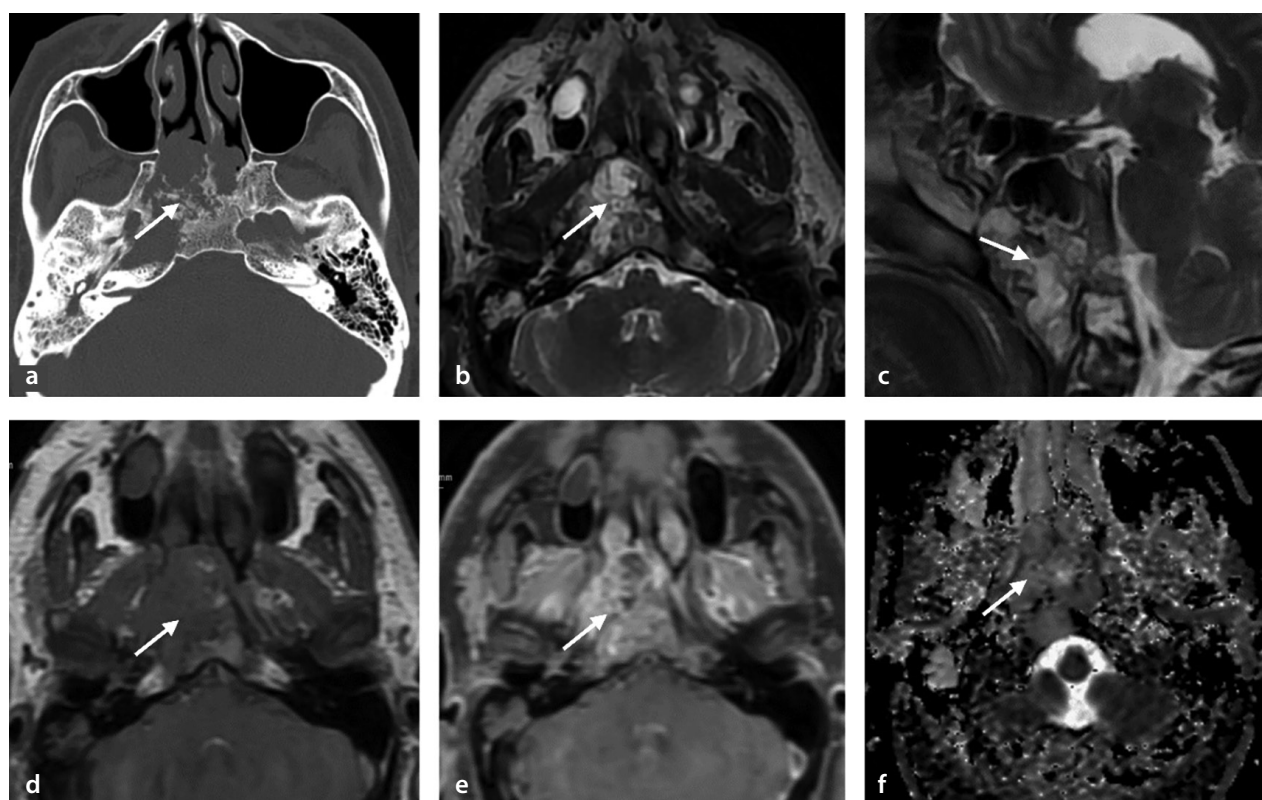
Imaging findings from a 60-year-old male patient who presented with hearing loss and sudden-onset diplopia, subsequently diagnosed with clival chordoma. Axial computed tomography image (a) reveals a lytic, destructive mass containing sequestered bone tissue (arrow). The T2-weighted magnetic resonance images (b, c) reveal a hyperintense lesion. The T1-weighted (T1W) image (d) demonstrates a hypointense lesion with hyperintense foci suggestive of hemorrhage. A post-contrast T1W image (e) displays moderate heterogeneous enhancement with a honeycomb-like pattern. On the apparent diffusion coefficient (ADC) map (f), the ADC value is measured at $1.595 \times 10^{-3} \text{ mm}^2/\text{sec}$. The patient received external beam radiotherapy following the surgical diagnosis of chordoma.
